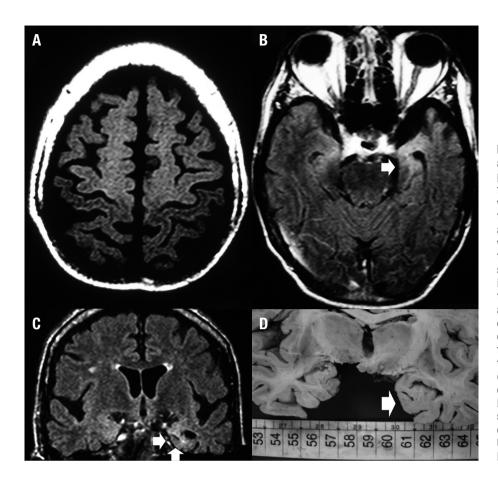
A man of 61 years of age presented with a history of progressive non-fluent aphasia in the four months prior to admission. This was followed by an asymmetrical flaccid tetraparesis, hyperreflexia in all four limbs, which was associated with a bilateral Hoffmann sign, and fasciculation. [A] Axial T1 MTC image showed an abnormal hyperintensity involving the cortical and subcortical frontal areas including pre-central gyri and the remaining subcortical regions of the frontal lobes. [B-C] Axial and coronal FLAIR images depicted left temporal lobe atrophy with blurring of the grey/white matter differentiation (arrows). [D] Brain macroscopy confirmed atrophy in the left temporal lobe (arrow). Left hippocampus cortex showed neuronal loss as well as cytoplasmic, nuclear and extracellular Ul inclusions, in addition to neuronal loss and astrogliosis (not shown).
